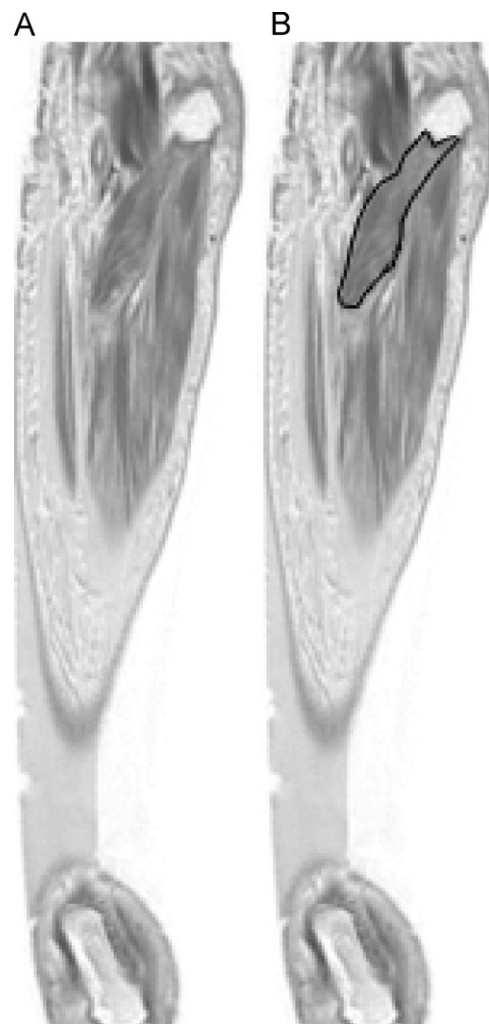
Sagittal image (inverted, fat-suppressed FSPGR) of the forearm showing PT muscle without (A) and with (B) the muscle border outlined. Manual segmentation required outlining each muscle in all MR images that contained the muscle in order to reconstruct muscle volume.
